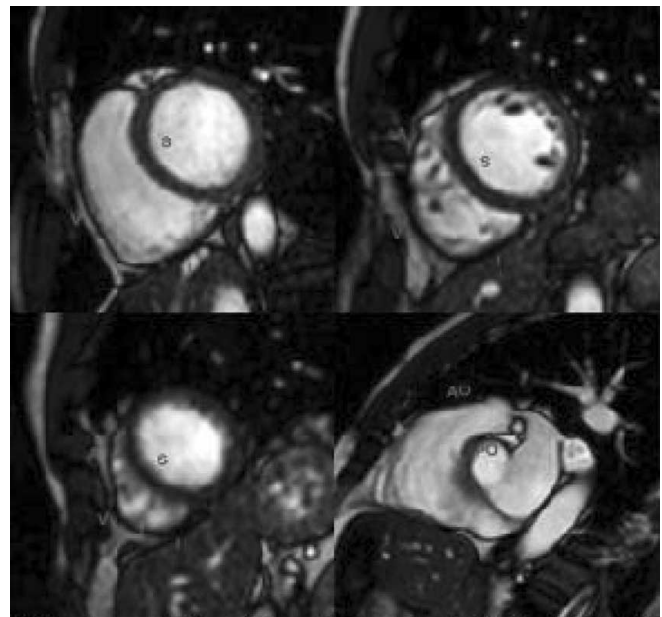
RV segmentation: Short-axis cine MR images at the basal, midventricular and apical levels as well as in the outflow tract plane (top left to bottom right) demonstrating the segmentation of the right ventricle. S = septal segment, I = inferior segment; V = ventral segment; A = anterior segment; AO = anterior outflow tract; PO = posterior outflow tract.
